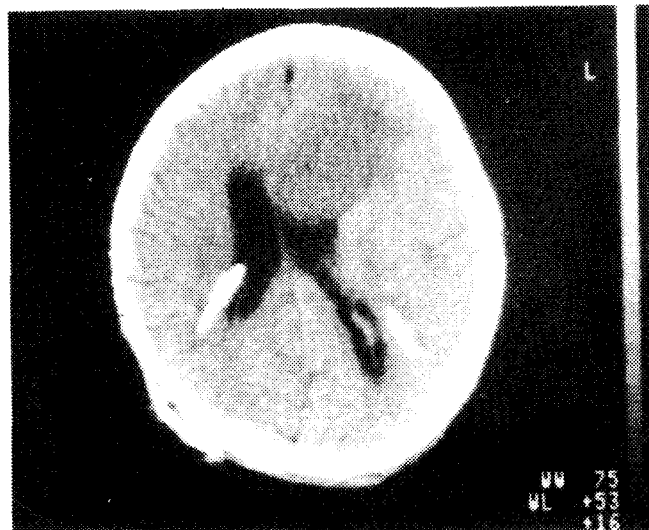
(Ib) : Post shunt CT head scan showing bilateral shunt through bilateral posterior parietal burrholes. (same patient Fig. I a).
